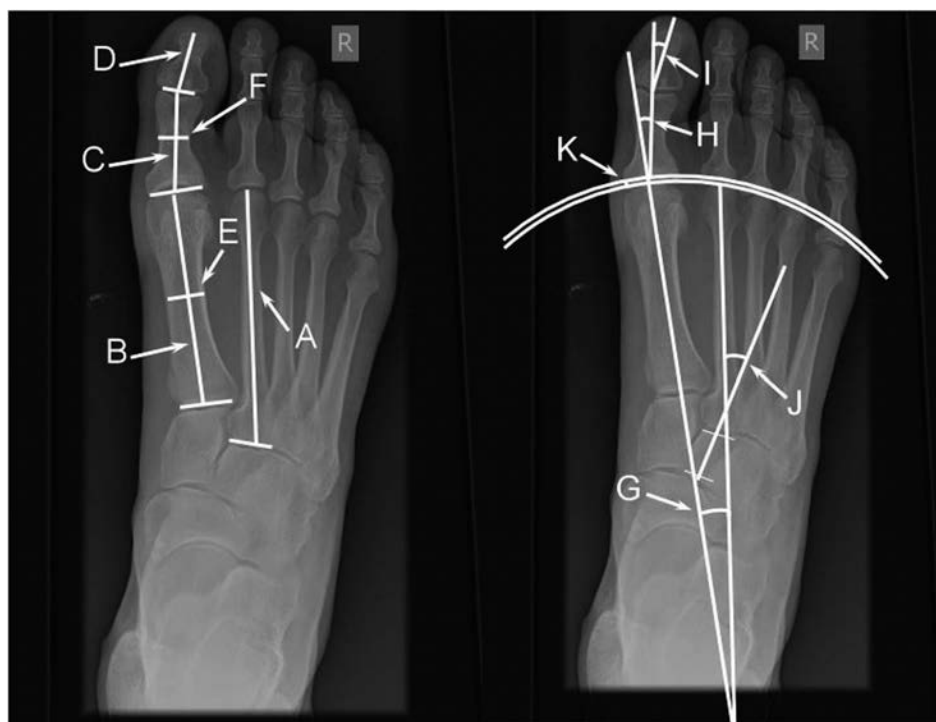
Dorsiplantar radiographic measurement techniques: bone length and width measurements. A, Second metatarsal length; B, First metatarsal length; C, Proximal phalanx length; D, Distal phalanx length; E, First metatarsal width; F, Proximal phalanx width. Dorsiplantar radiographic measurement techniques: angle measures; G, Intermetatarsal angle; H, Hallux abductus angle; I, Hallux abductus interphalangeal angle; J, Simplified metatarsus adductus angle; K, Metatarsal protrusion distance.
